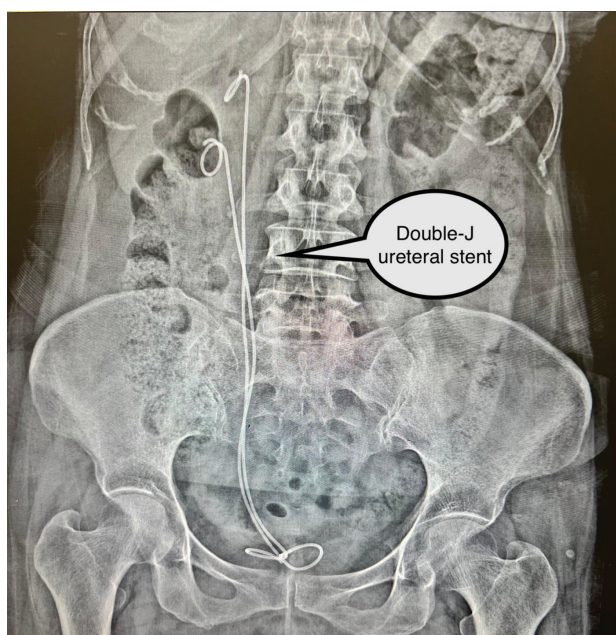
Postoperative day 1 follow-up plain urinary system radiograph showing double-J stents placed in both right ureters.
